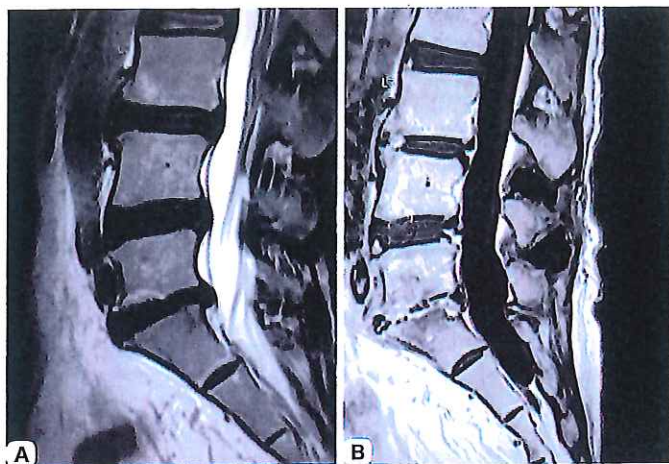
Pretreatment MRI
